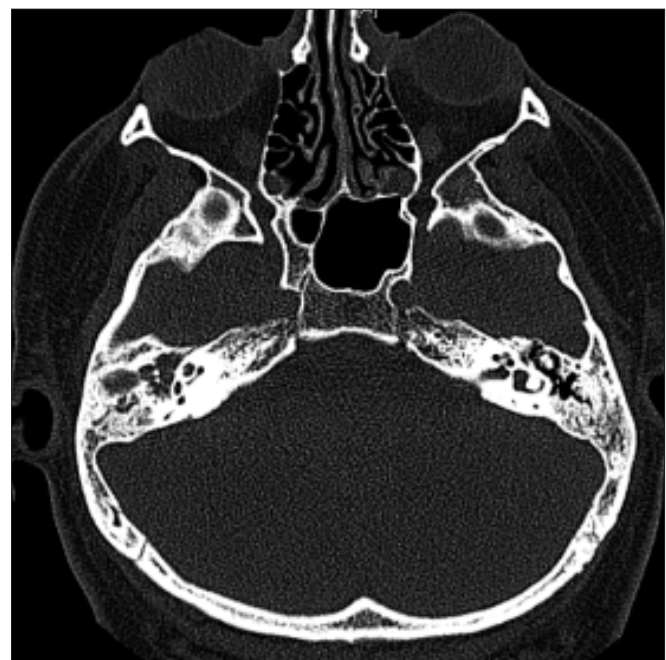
Axial CT scan of the temporal bones demonstrating soft tissue in the right middle ear. Note the patent mastoid air cells on the left (normal) ear. The soft tissue was identified as cholesteatoma at surgery.
